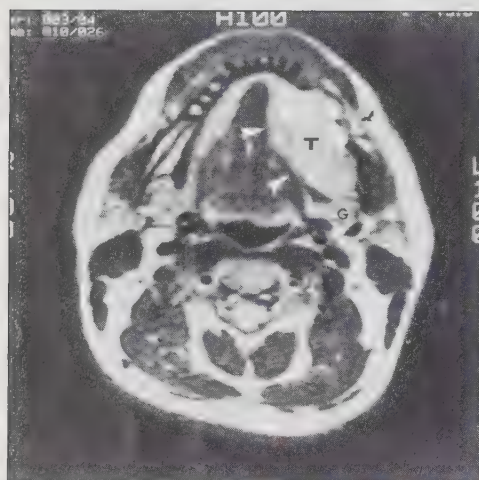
(Case 3): MRI - T2 weighted axial image. A well-delineated high-signal intensity heterogeneous mass (T) is noted. Medial and lateral cortical destruction is noted in conjunction with extensive medial and submandibular soft tissue invasion (arrows). Note relationship of tumor (T) to submandibular gland (G). Multiple positive mucosal and bone biopsies confirmed the MRI impression of extensive soft tissue and mucosal invasion.
